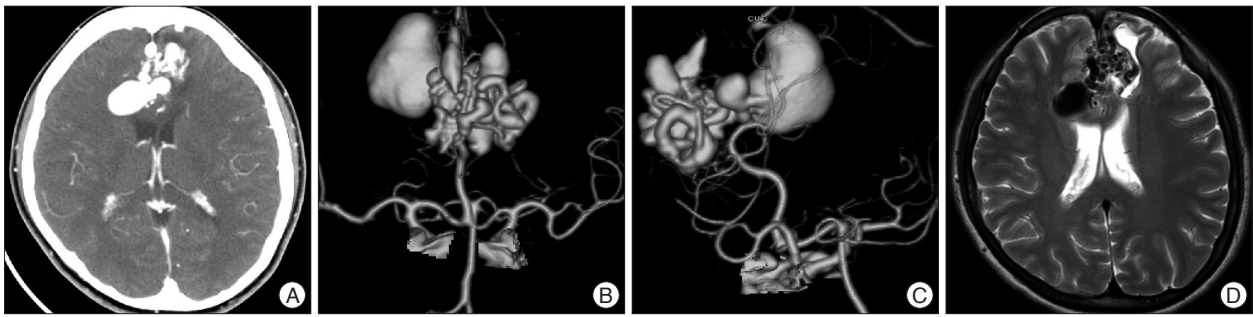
Brain CT scan with contrast enhancement (A) showing saccular and irregular tubular contrast enhancement on both frontal lobes above the corpus callosum. CT angiogram (B and C) demonstrates giant aneurysm on right frontal lobe fed by azygos ACA and multiple conglomerated lesions on both frontal lobes across the midline suggesting venous varices. T2 weighted MR image (D) shows irregular conglomerated signal void lesions on both frontal lobes, and large oval shaped signal void aneurysmal sac on right frontal lobe without mass effect. CT : computed tomography, ACA : anterior cerebral artery, MR : magnetic resonance.
